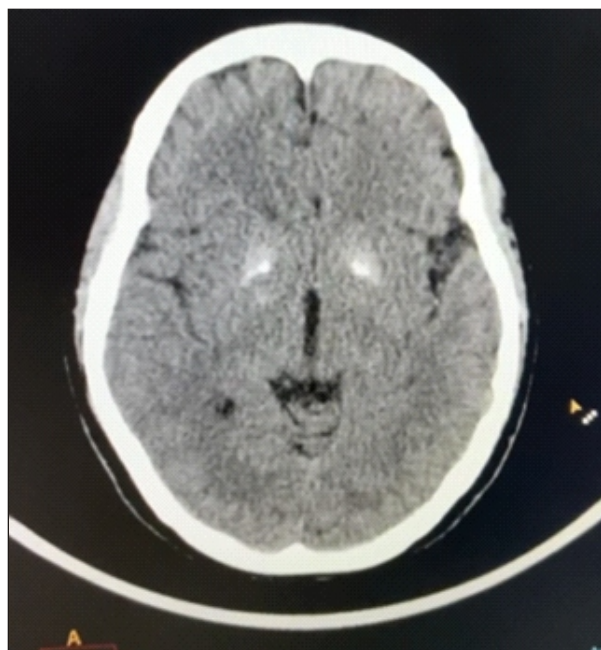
CT Brain Transverse view showing bilateral basal ganglia calcification
